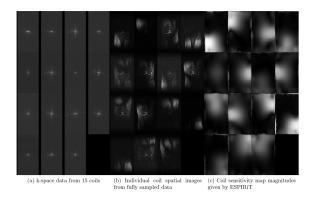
Multi-coil MRI reconstruction [8].
